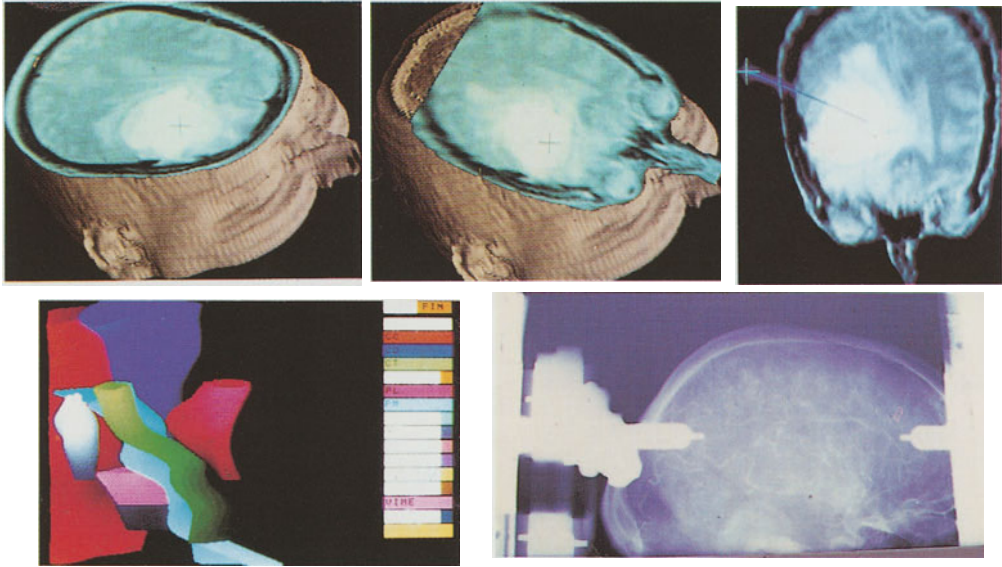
Definition of the strategy on multimodality information. A target point and a linear trajectory are selected on reformatted slices of 3D NMR images (up), on an anatomical Atlas which has been digitized and segmented into surfaces of structures (down left) and on orthogonal X-ray images such as ventriculograms and angiograms (down right).
